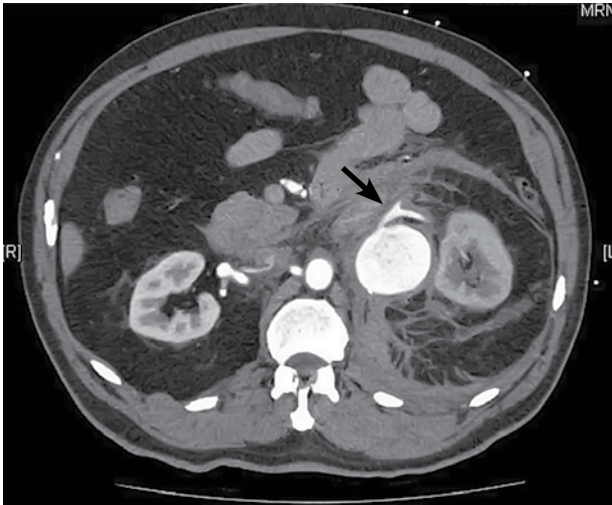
Computed tomography angiography in arterial phase showed a 4.6 cm left renal artery aneurysm with stranding of the perinephric fat. Twenty minutes later the patient was haemodynamically unstable. The branch that emerges from the aneurysm needed to be sacrificed (arrow).
